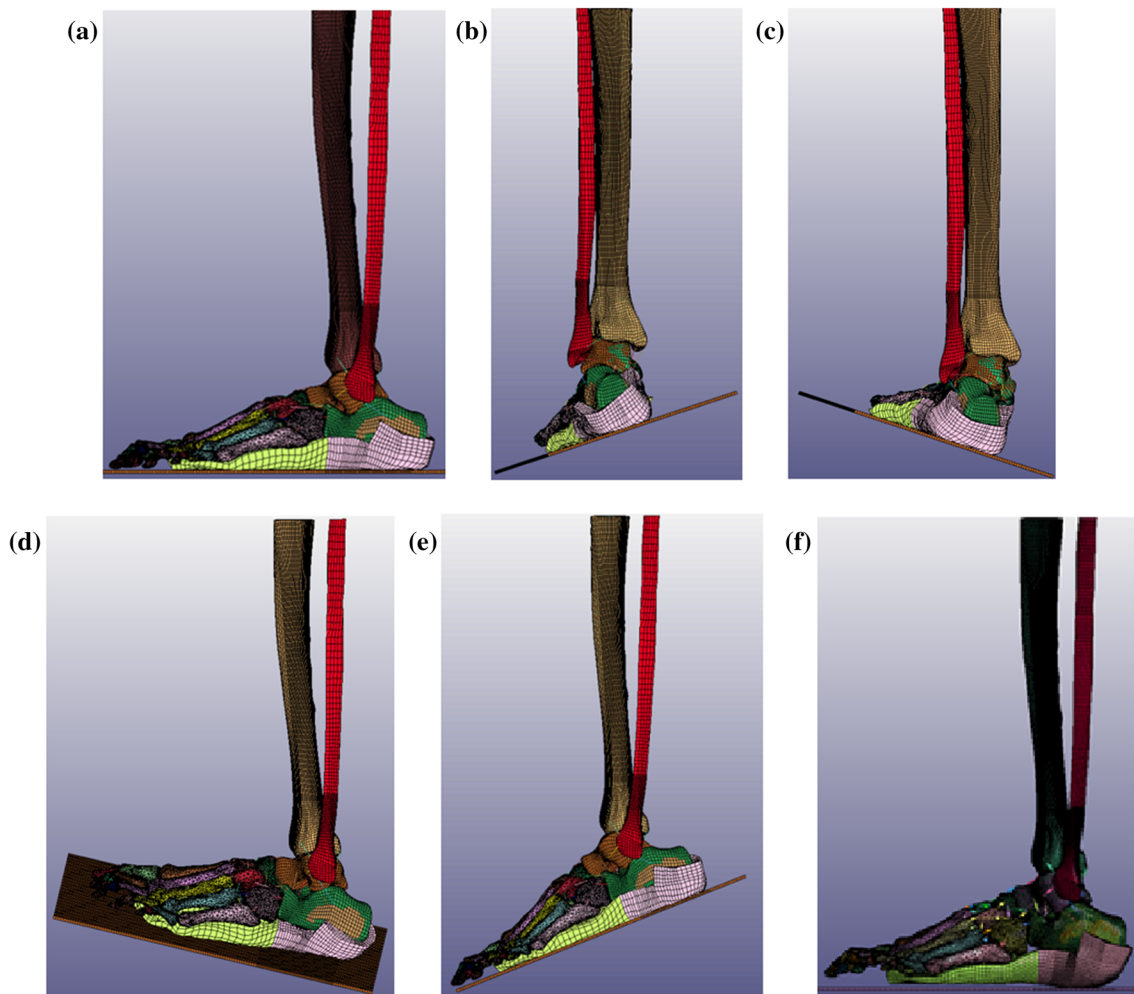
The complete lower leg FE model in the five ankle postures. The ankle is shown in the five ankle postures that were tested: neutral (a), 18° of inversion with 10° of external rotation (b), 18° of eversion with 10° of external rotation (c), 13° of dorsiflexion with 18° of inversion (d) and 22° of plantarflexion (e), as well as the refined mesh that was created for the neutral posture (f). These postures resulted from attaching the footplate to the plantar surface of the FE model foot and rotating the footplate by the specified angles about the centers of rotation determined experimentally from the CT scans.
